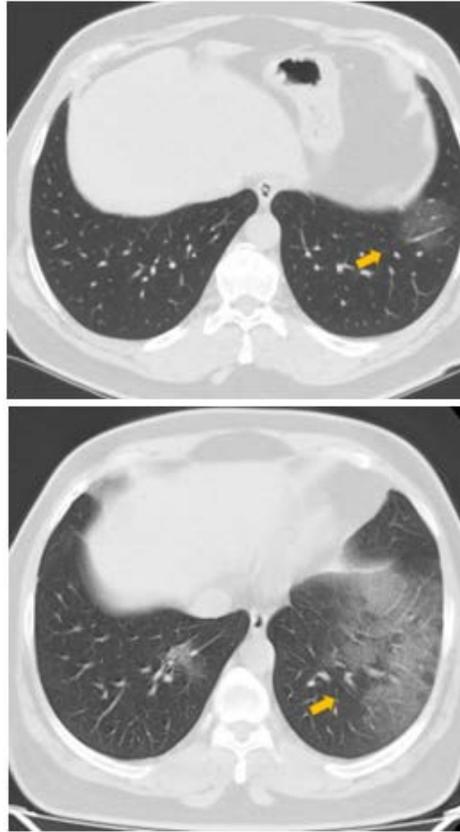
Axial CT scans in 49-year-old man with COVID-19. (a) Scan obtained on day 5 of illness shows diffuse ground-glass densities that affected left lower lobe. (b) Scan obtained on day 11 of illness shows that an increase in the areas of ground glass densities is observed (yellow arrow)
